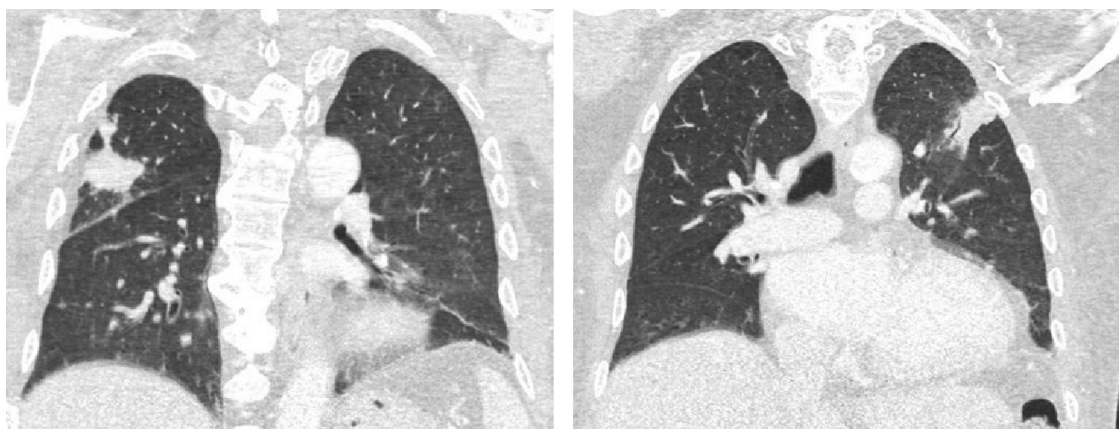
CT scan showing two bilateral consolidated opacities in the right (left panel) and left (right panel) upper lobes.
